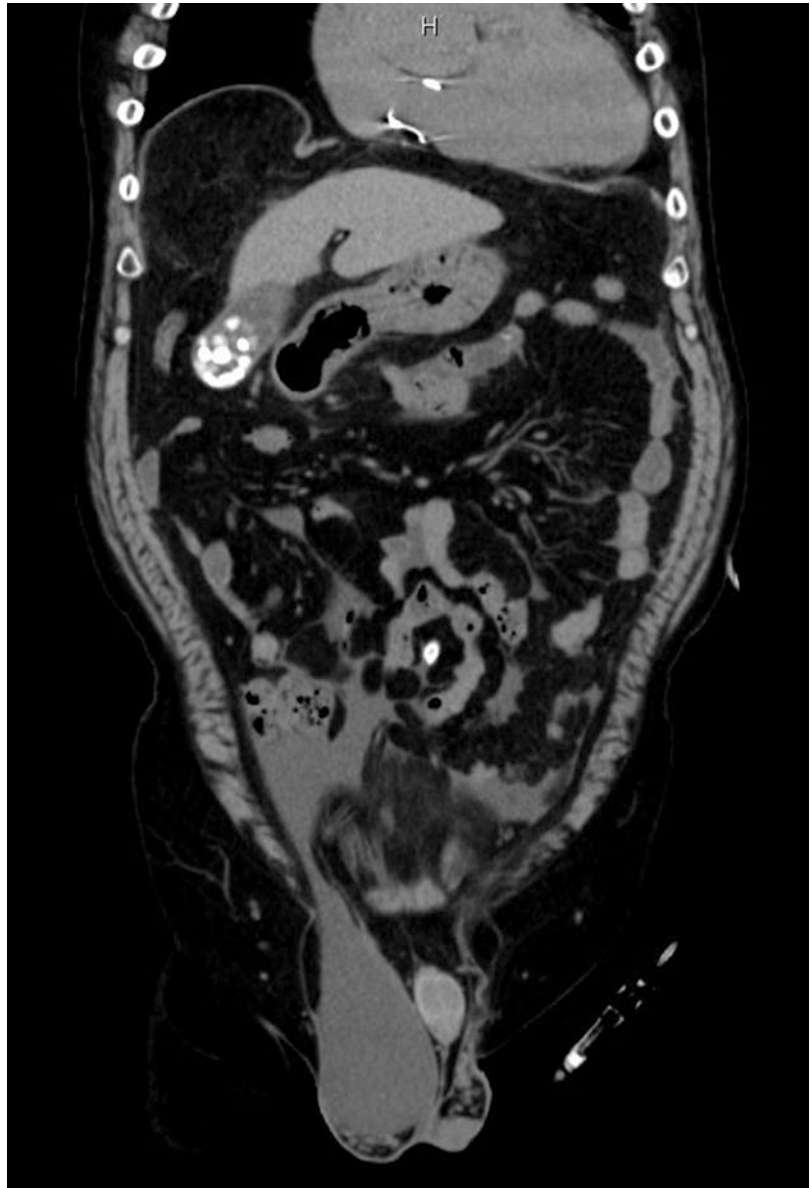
A CT scan of indirect inguinal hernia exhibiting peritoneal fluid connecting the peritoneal cavity with the testis in a PD patient (coronal plane)
